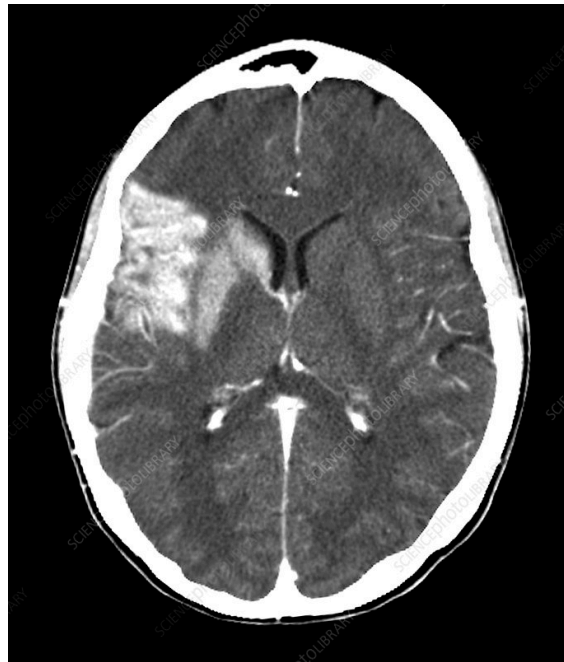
An example of a CT scan
